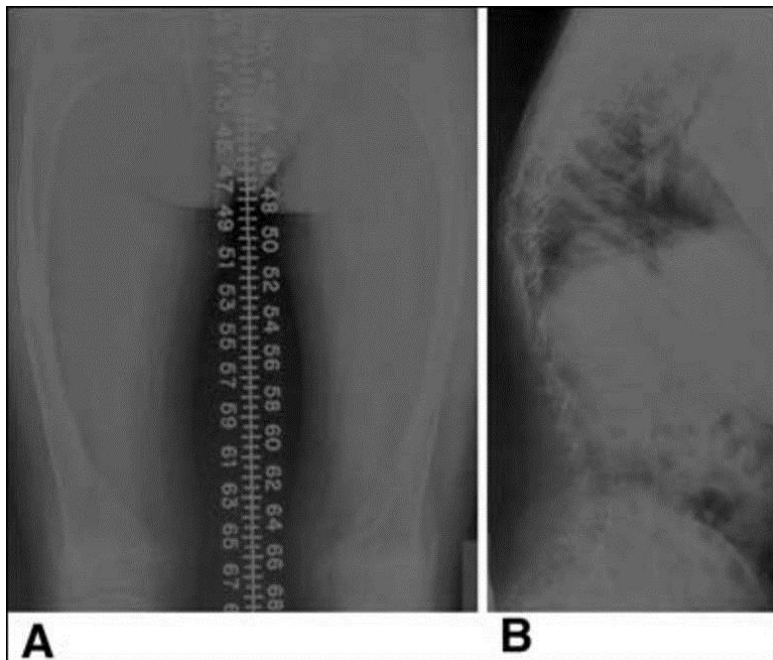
Radiographs of lower extremities of type IV OI child. Shows mild bowing and placement of Rush rod. B: Lateral view of spine shows milder scoliosis and milder compression of vertebrae.
